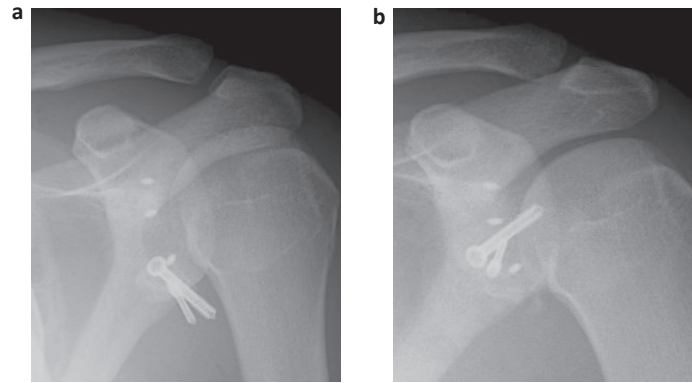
Case II. A 20-year-old male treated with the Latarjet procedure due to a previously failed Bankart repair. An early X-ray revealed malposition of the screws (a). The fixation was corrected (b).
